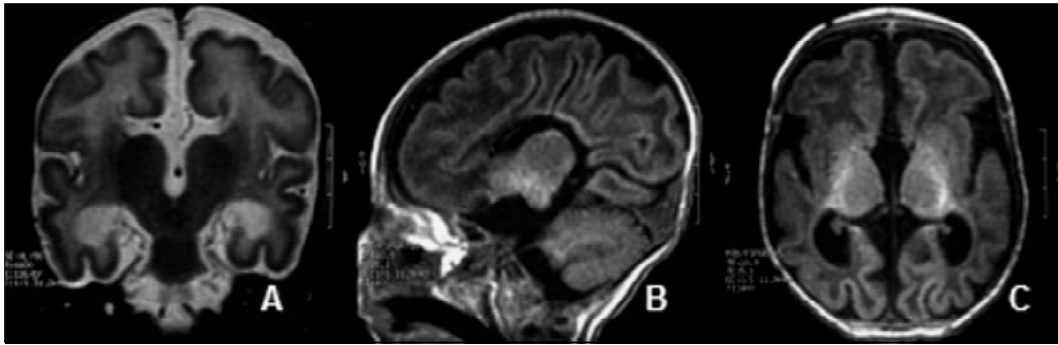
MRI showing diffuse pachygyria, moderate thickening of the cerebral cortex, enlarged ventricles, agenesis of the corpus callosum and septum pellucidum on T2-weighted coronal (A), FLAIR sagittal (B) and FLAIR axial (C) cuts.
